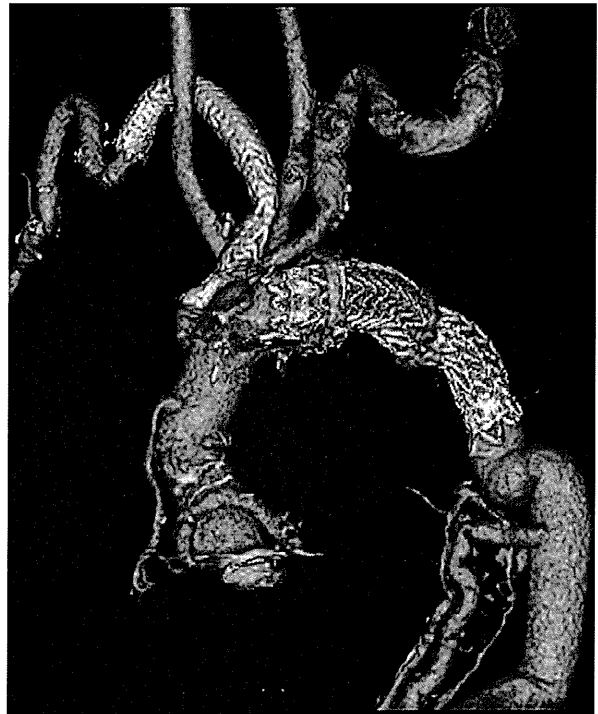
Computed tomographic scan obtained after the hybrid repair shows that all bypasses are patent and that the aneurysms are completely excluded from the blood flow.
